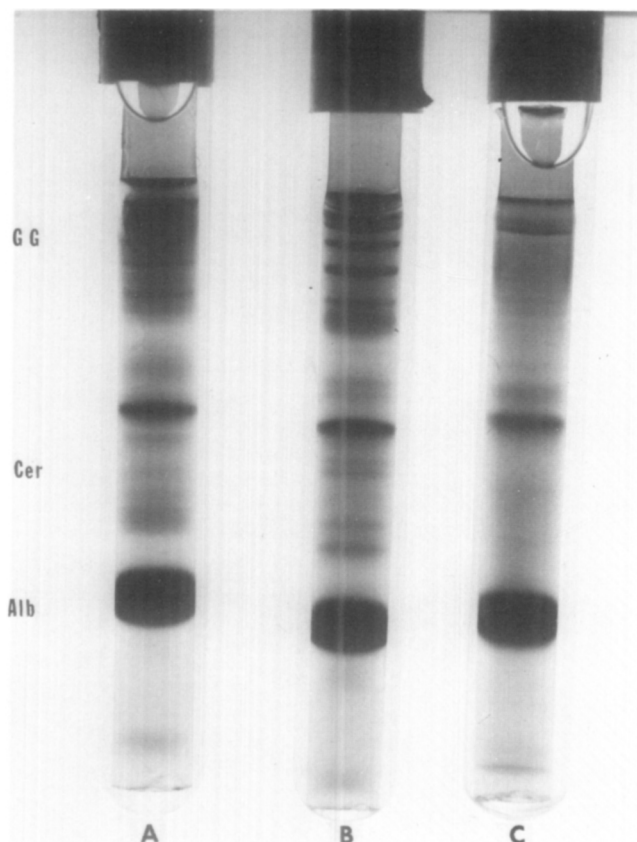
Polyacrylamide-gel electrophoretic patterns from Case 4; radicular cyst. *A*, Fingertip plasma. *B*, Periapical plasma. *C*, Root canal fluid. *Alb*, Albumin; *Cer*, ceruloplasmin region; *GG*, gamma globulin region.
